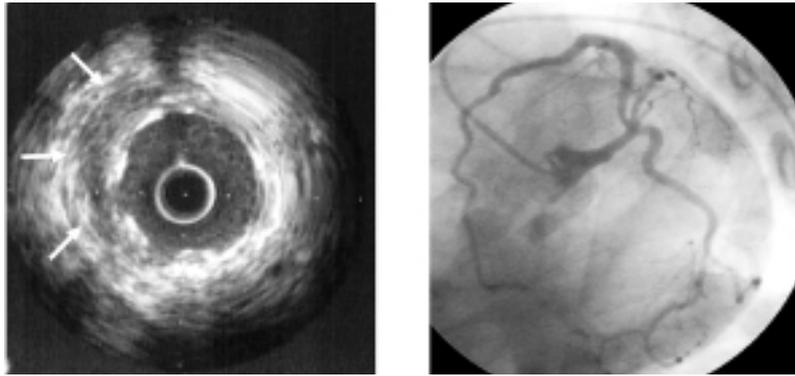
Left panel: following stent implantation, intravascular ultrasound showed a widely patent stent with partial compression of the intramural hematoma (arrows). Right panel: the final angiogram (spider view) showed a sealed dissection with the restoration of a pristine distal blood flow.
